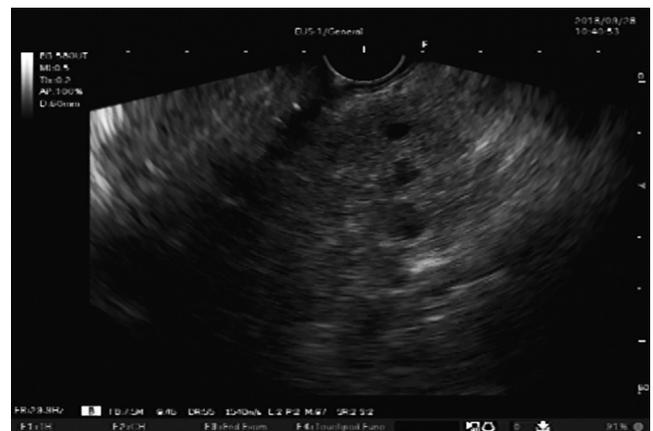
Echogenic bands in Olympus linear endosonography (image courtesy of the Union of Surgeons SAS, Lázaro Arango).
